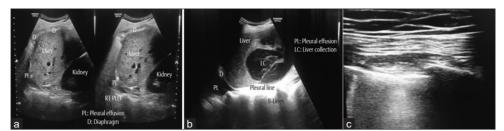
(a) Point-of-care ultrasound (POCUS) showing the relations of right lung, liver, and right kidney. A small right-sided pleural effusion. (b) POCUS showing large hepatic collection and a right-sided pleural effusion. (c) Confluent multiple B-lines suggesting pneumothorax on extracorporeal membrane oxygenation.
